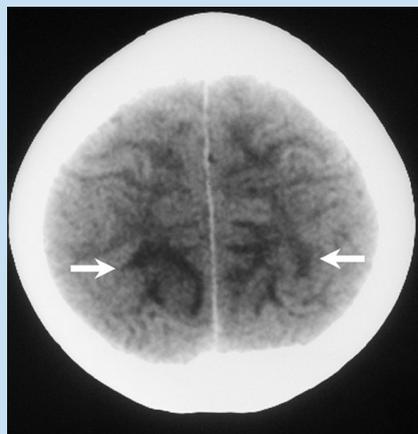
Axial post-contrast CT scan of the brain shows subtle parasagittal white matter low densities in the high parietal regions (arrows).
